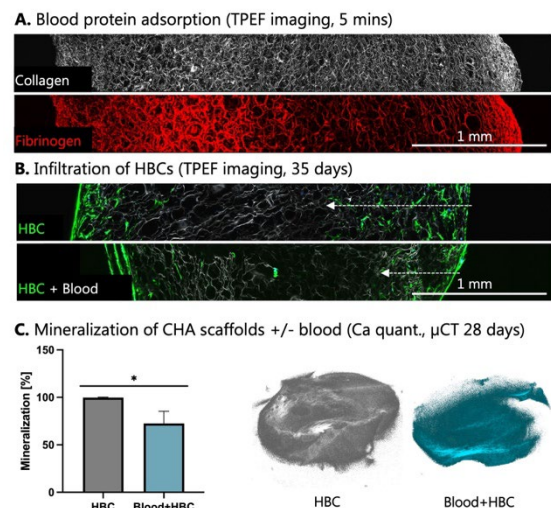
Cross-section of CHA scaffolds showing (A) the adsorption of blood proteins, and (B) the impairment of HBC infiltration. (C) Ca^{2+} quantification and μ CT reconstructions show that blood limits mineralization.
